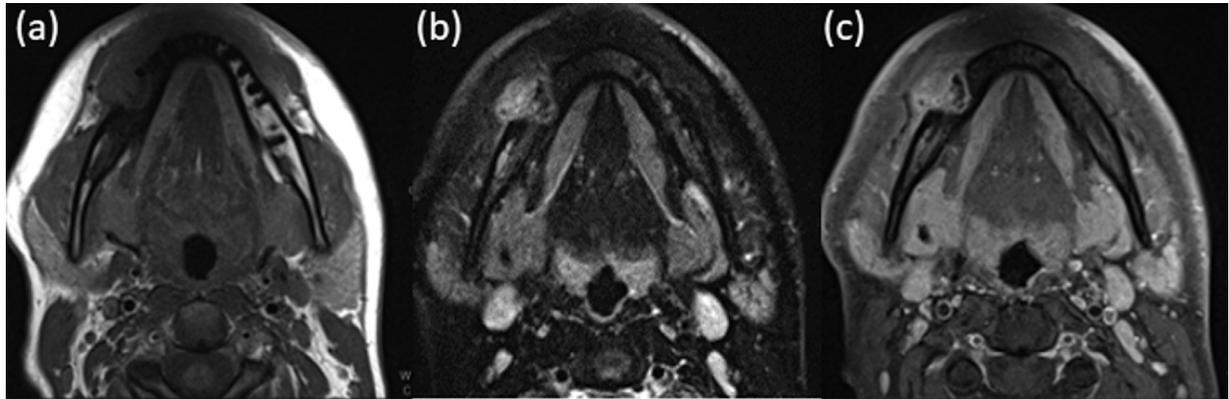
Axial T1-weighted image (A), axial signal intensity on short tau inversion recovery (STIR) (B), and axial T1 fat saturation image with gadolinium (C) show the eccentric expansile lesion arising from right hemi-mandibular body with destruction of the outer mandibular cortex and extraosseous submucosal extension. The lesion exhibited low intensity on T1-weighted sequence, predominantly high signal intensity on STIR, and strong enhancement on injection of gadolinium contrast.
